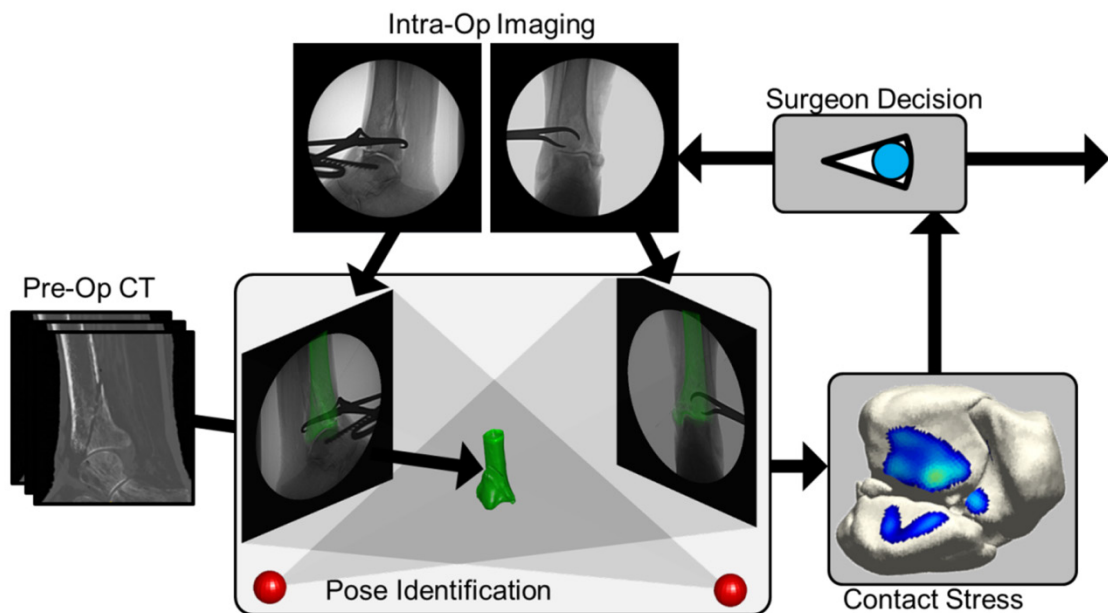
Proposed intra-operative contact stress assessment system uses pre-operative CT scans and intra-operative bi-plane imaging to determine the pose of fracture fragments, predict contact stress of fragments in these positions, and display results to the surgeon. The surgeon can use these results to determine progression through the reduction.
